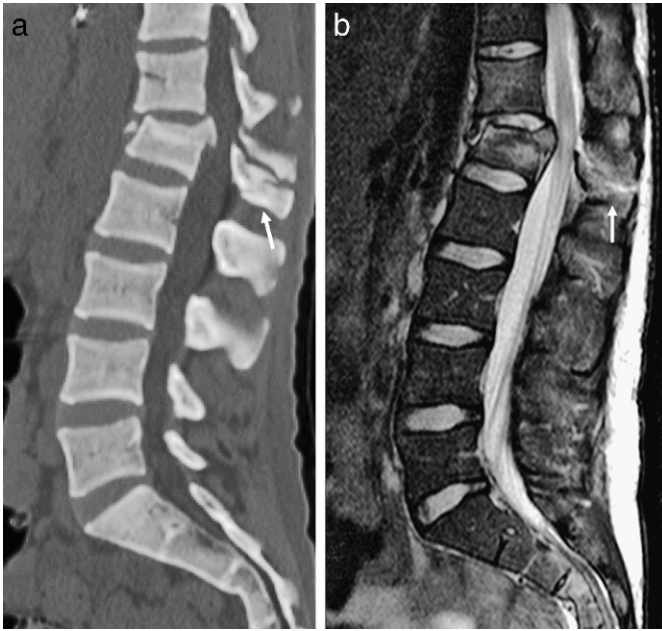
Chance-type fracture. (a) Sagittal CT demonstrates compression deformity of the L1 vertebral body with distraction of the posterior elements (arrow). (b) Sagittal T2-weighted image demonstrates the compression deformity of the L1 vertebral body, as well as edema within the posterior elements (arrow). Note that the retropulsed fragments compress the conus medullaris with mild associated edema.
